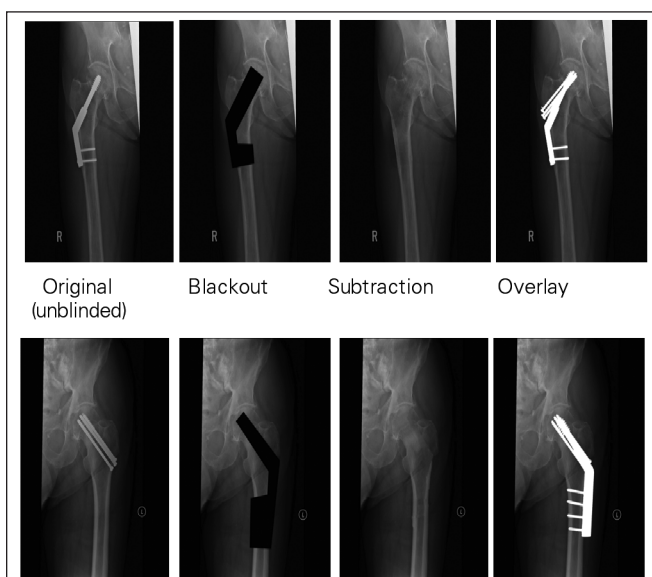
Example of creative techniques to blind radiographs of femoral neck fracture reduction, fixated with either a dynamic hip screw or 3 cannulated screws.
